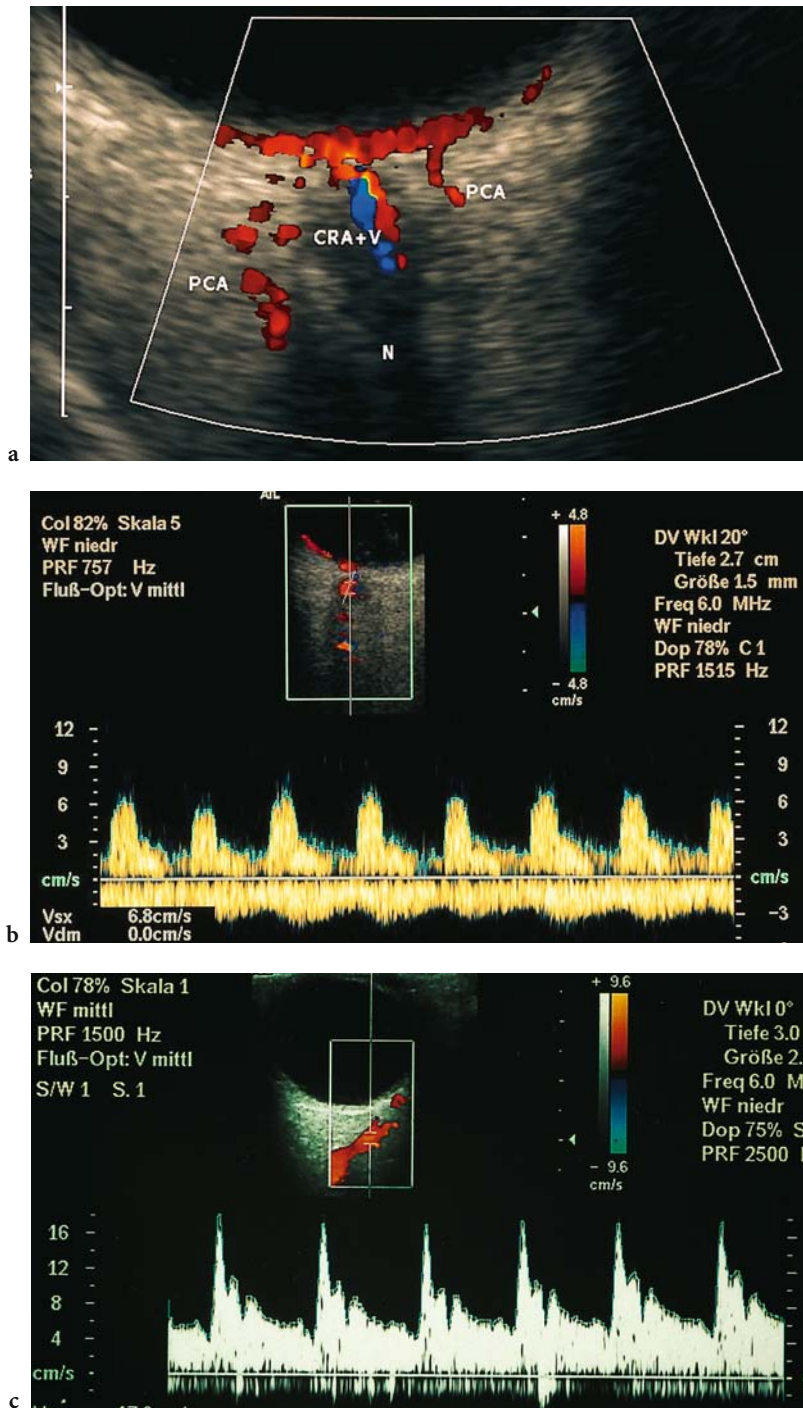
a Horizontal section through the globe at the level of the optic nerve. Displayed are the central retinal artery (CRA), the central retinal vein (CRV), and the temporal short posterior ciliary artery (PCA). b Analysis of the Doppler spectrum. A cursor is placed on the vessel, and the angle is corrected according to the vessel's course. The spectrum of the CRA shows usually venous overlap caused by the CRV running close to the CRA. c Doppler spectrum and course of the ophthalmic artery
